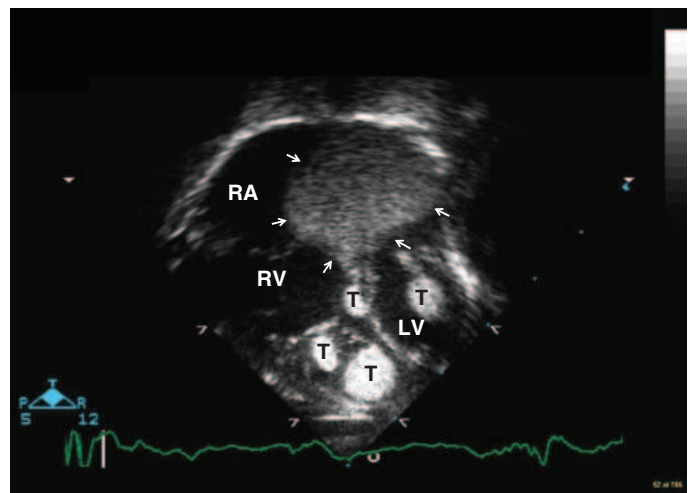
Transthoracic echocardiogram revealing multiple tumors (T) consistent with rhabdomyomas in a 1-day-old infant. The largest tumor (arrows) was located in the left antioventricular groove and measured 2 cm × 2 cm. LV, left ventricle; RA, right atrium; RV, right ventricle.
